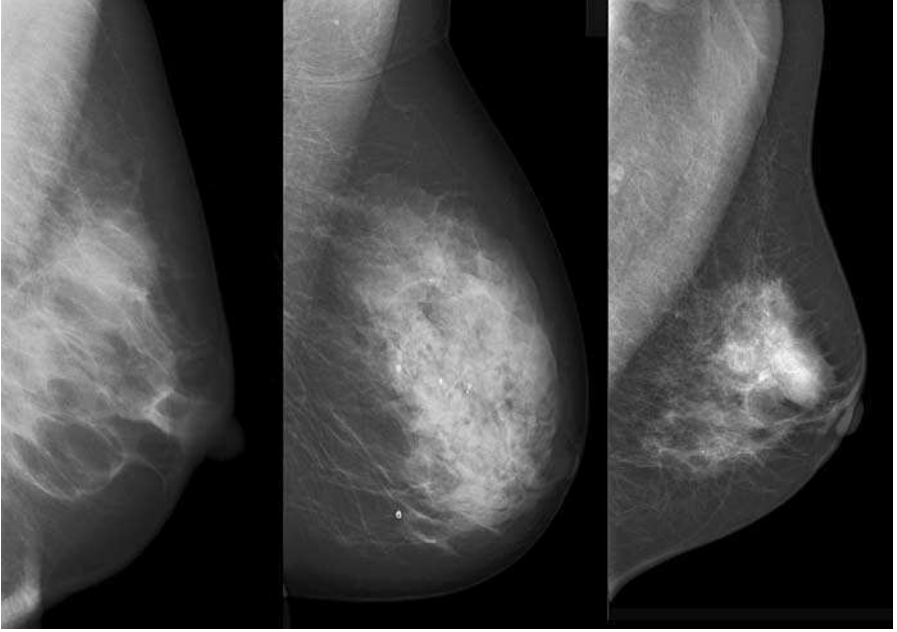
Examples of x-ray mammograms from different modalities. A digitized film with high spatial resolution but low contrast (left), a digital luminescence radiograph that exhibits strong noise (center) and a direct digital mammogram with high contrast and low spatial resolution (right).
